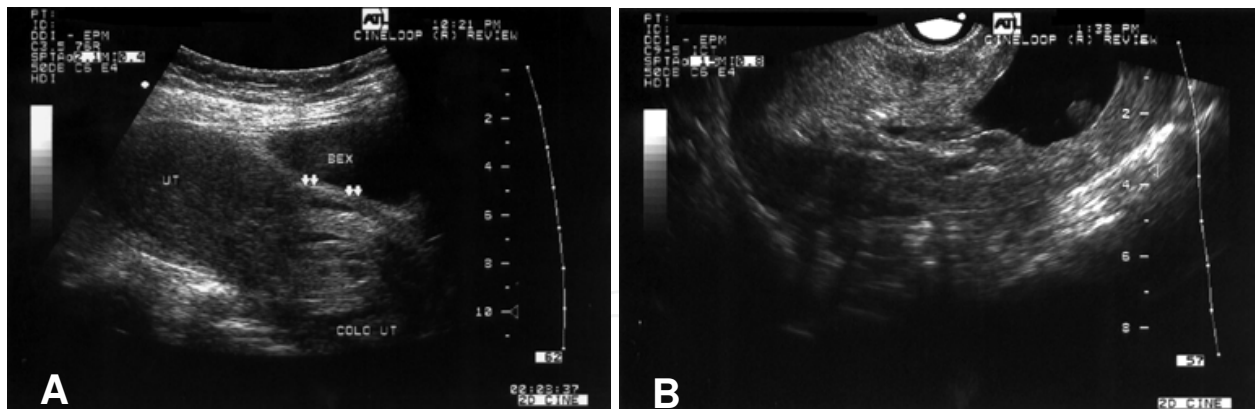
A) Longitudinally oriented transabdominal ultrasound of cervical pregnancy showing an empty uterine cavity, hourglass uterine shape, placental tissue in the cervical canal and closed internal os. B) Longitudinally oriented transvaginal ultrasound showing an empty uterine cavity, hourglass uterine shape, gestational sac in the endocervix and closed internal os (Elito et al., 1999b).
